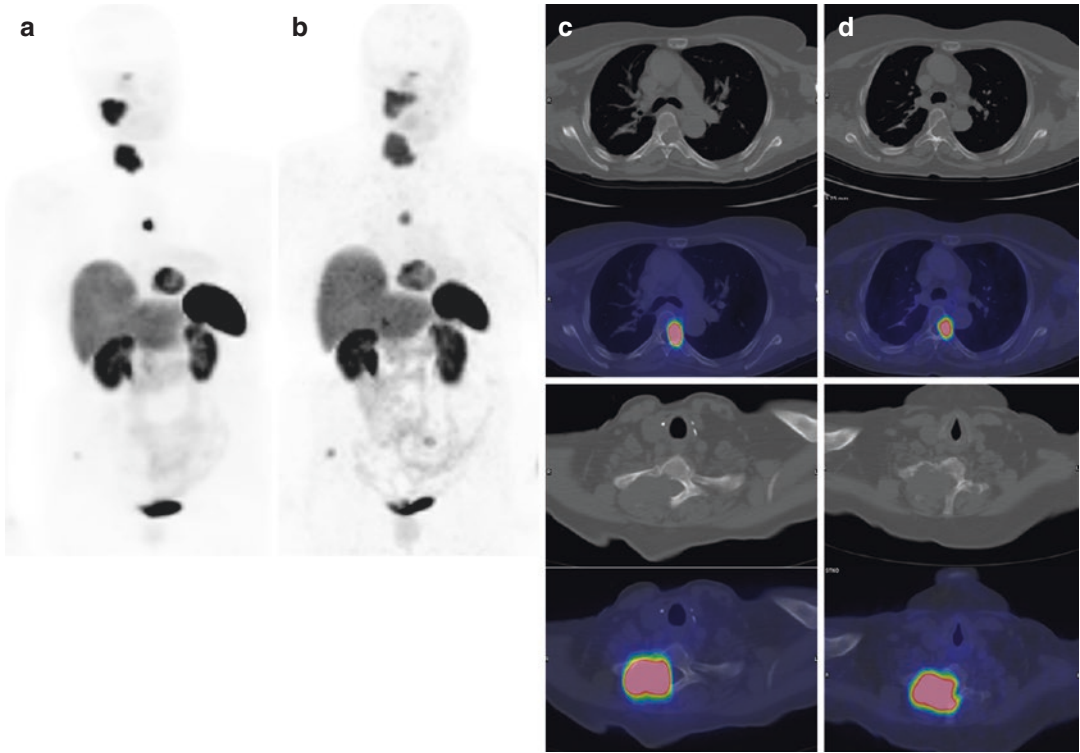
Patient with medullary thyroid carcinoma. ^{68}Ga -DOTATOC PET/CT at baseline (a, c) demonstrated multiple sites of pathological uptake in lymph nodes and bone. The patient underwent six cycles of ^{90}Y -DOTATOC
